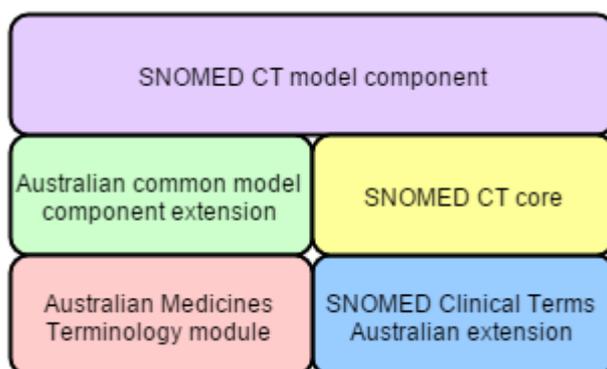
Module composition for SNOMED CT-AU combined with the AMT
